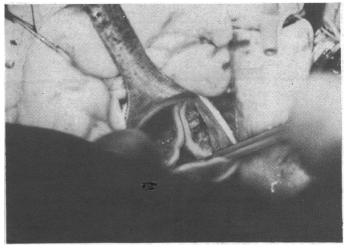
Case 1. Result of ultrasonic decalcification. Normal-appearing valve with granular areas remaining where calcium had been.
